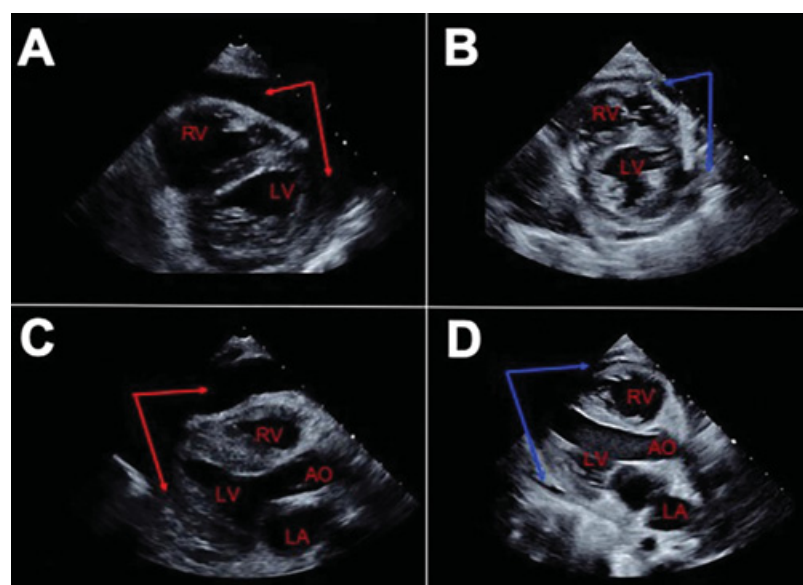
Echocardiographic images before and after pericardiocentesis. (A) Parasternal short axis view with large pericardial effusion (red arrows). (B) Parasternal short axis view post-pericardiocentesis showing resolution of pericardial effusion (blue arrows). (C) Parasternal long axis view with large pericardial effusion (red arrows). (D) Parasternal long axis view post-pericardiocentesis showing resolution of pericardial effusion (blue arrows). AO, aorta; LA, left atrium; LV, left ventricle; RV, right ventricle.
